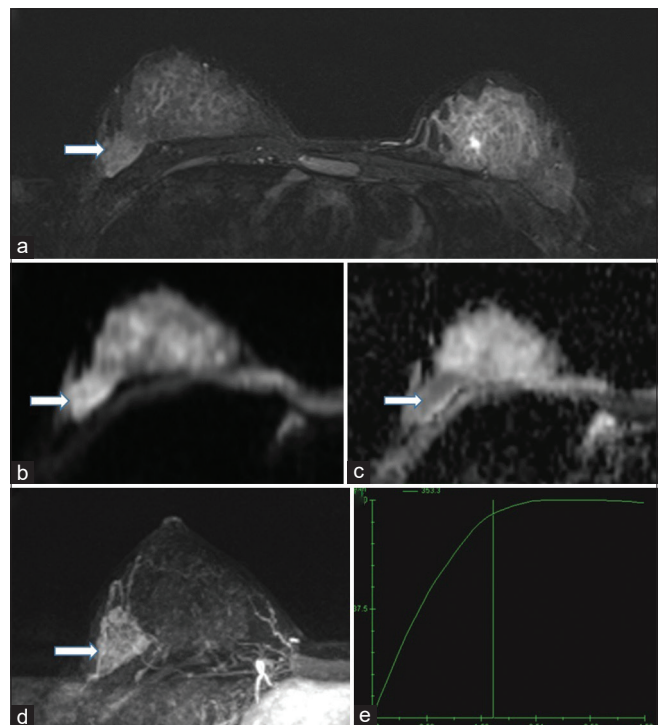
A 21-year-old Vietnamese woman with a palpable tumor in her right breast. A hyperintense lesion (arrow) was seen on short tau inversion recovery (a). A restricted diffusion lesion was seen via diffusion-weighted imaging (b) and the apparent diffusion coefficient map (c). The lesion (arrow) showed a fast-initial increase on dynamic T1-weighted imaging with contrast enhancement, followed by a plateau enhancement in the delayed phase (d and e).
